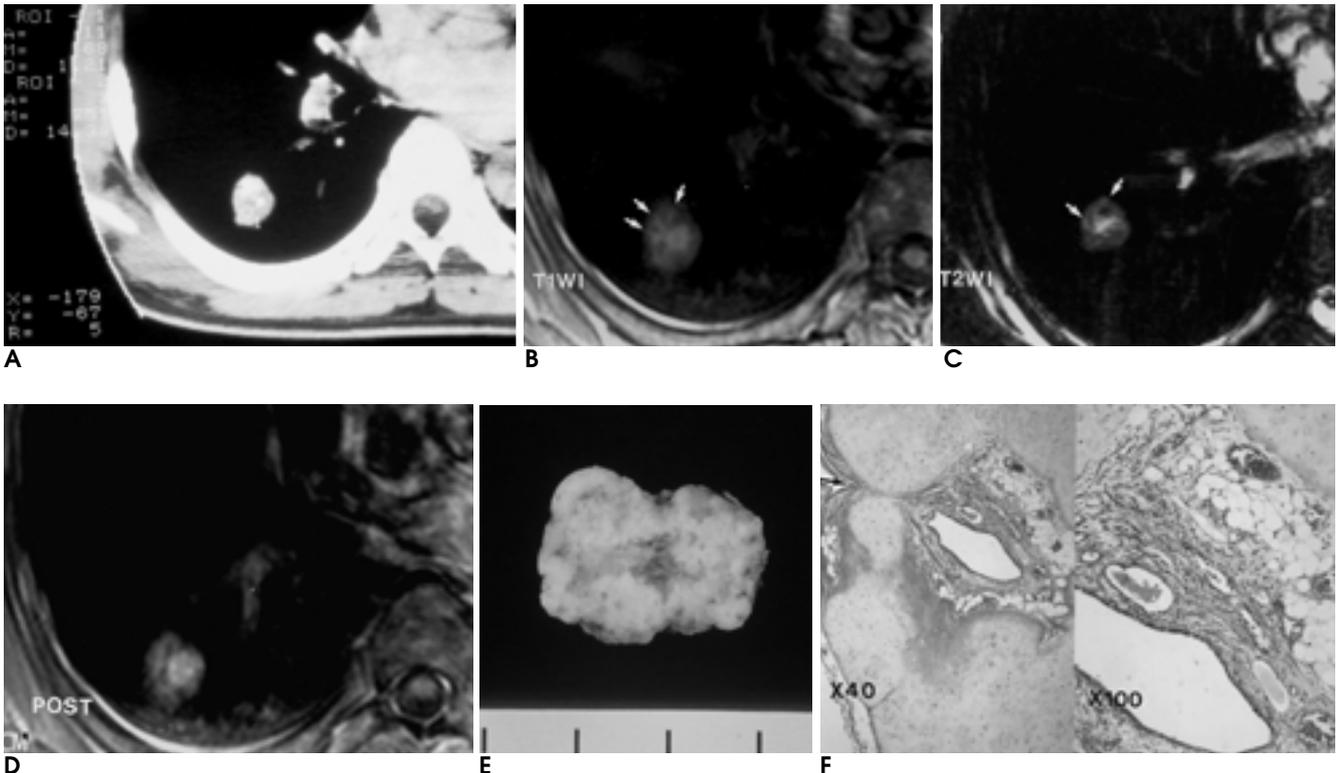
50- years old male patient of case number 2. CT scan (A) shows a nodule with small popcorn shaped calcification without fat component by densitometry. Routine T1 and T2WI (B, C) show heterogeneous nodule of intermediate SI pathologically revealed mature chondroid hamartoma (F). The centrally cystic portion and peripheral stripes (B, C, arrows) of the nodule with high SI on T1 and T2WI are pathologically correlated with multiple cleft structures (E, F, arrow) including multifocally collected fat component and other mesenchymal component. Same degree of enhancement at the central and peripheral portion of the nodule is seen after Gd-DTPA IV injection (D) is pathologically correlated with relatively even distributed blood vessels (F).
